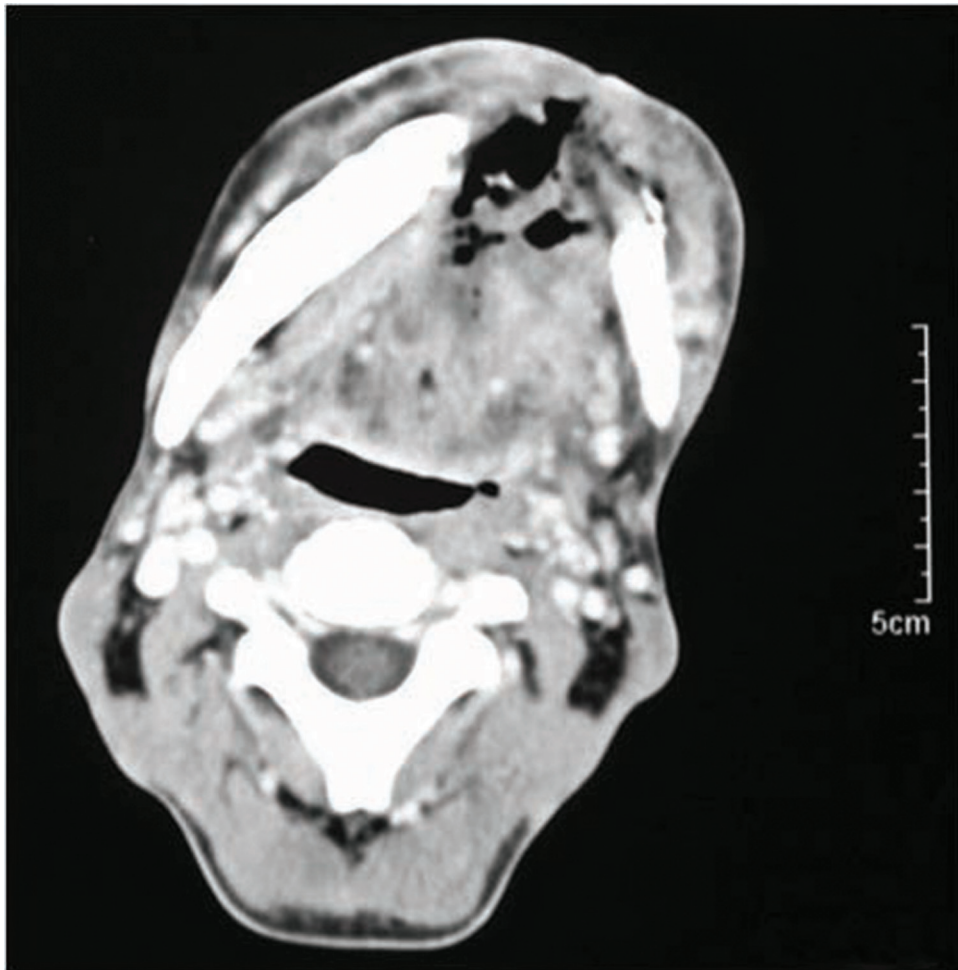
Axial CT scan reconstructed shows soft-tissue mass in anterior alveolar ridge. Mass extends posteriorly into the floor of the mouth. CT scan was interpreted as showing mandibular invasion with infiltration of adjacent subcutaneous tissue and loss of anatomical planes.
